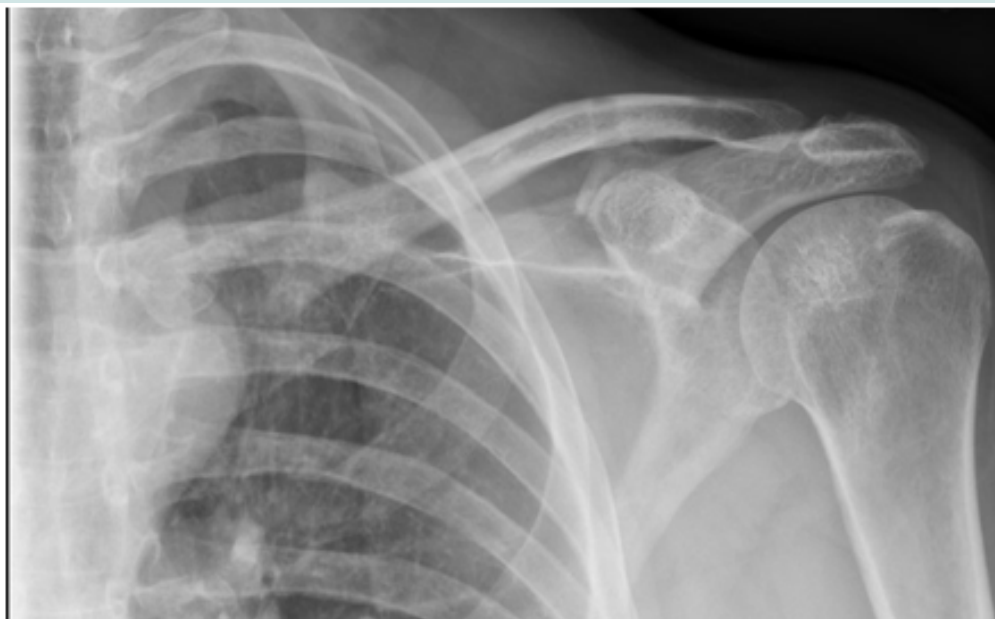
AP radiograph of the left clavicle four months from initial surgery without evidence of failure of his coracoclavicular ligament reconstruction or medial clavicle.
